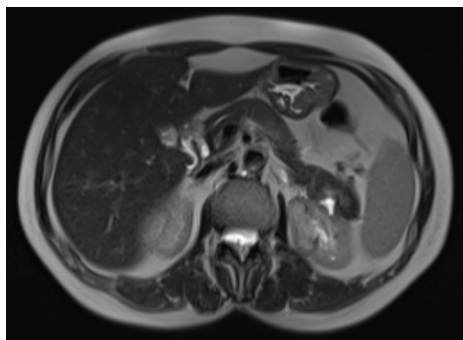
Axial T2 weighted (Contrast-enhanced abdominal magnetic resonance images of the patient)
